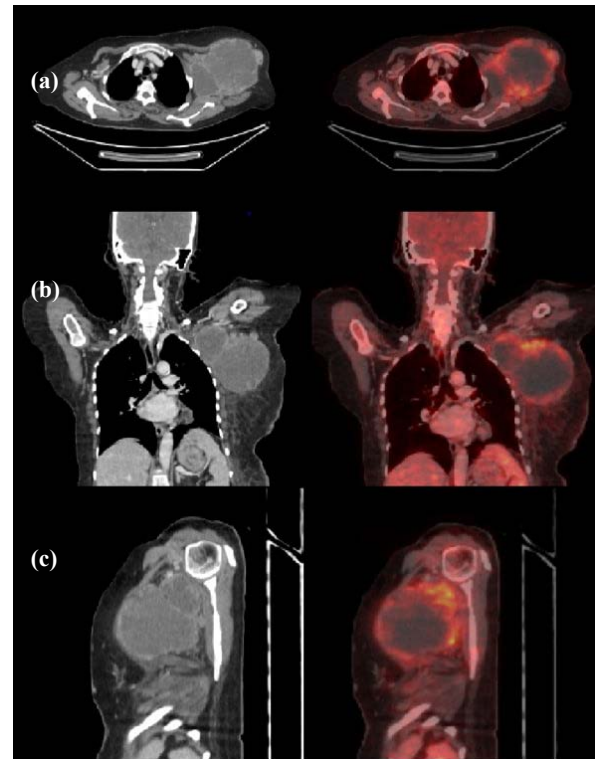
Computed tomographic (CT) images (left panel) and 18-fluoro deoxy glucose - positron emission tomography [FDG-PET] - CT fused images (right panel) showing intense uptake (SUV max-10.2) with central necrosis in left infraclavicular region and axilla of size 11.3×10.5 cm in axial (a): coronal (b): and sagittal (c): planes.
